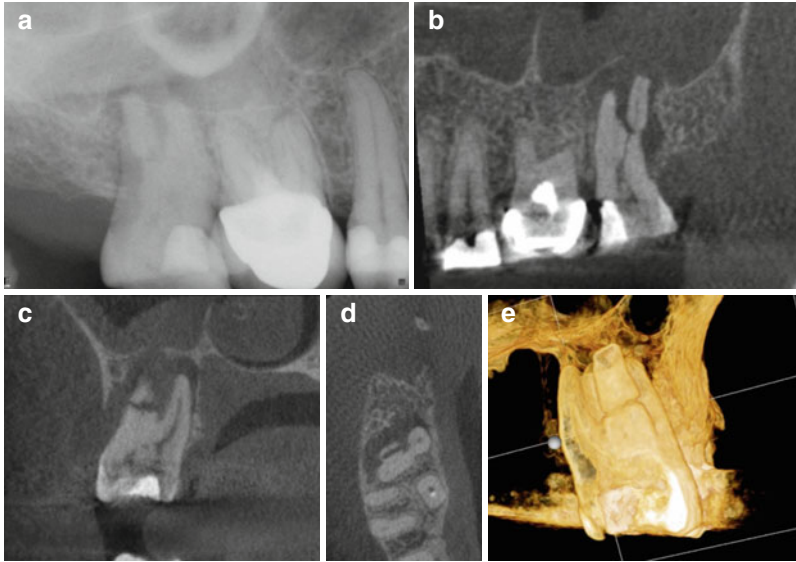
(a) Periapical radiograph of tooth #2. The patient was referred for nonsurgical root canal treatment with a diagnosis of pulp necrosis and asymptomatic apical periodontitis. (b) Sagittal view showing the distobuccal root fracture. (c) Coronal view showing the unusual horizontal fracture of the distobuccal root. (d) Axial view of the apical one third showing a vertical buccopalatal root fracture. (e) 3D reconstruction showing the extent of the distobuccal root fracture
